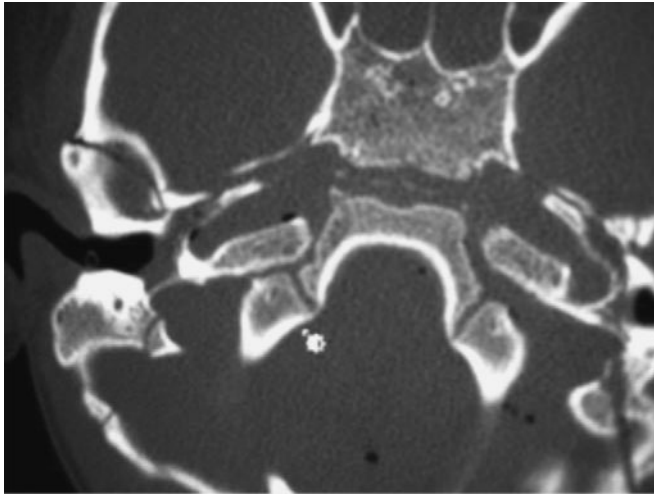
CT scan showing basilar skull fractures.
